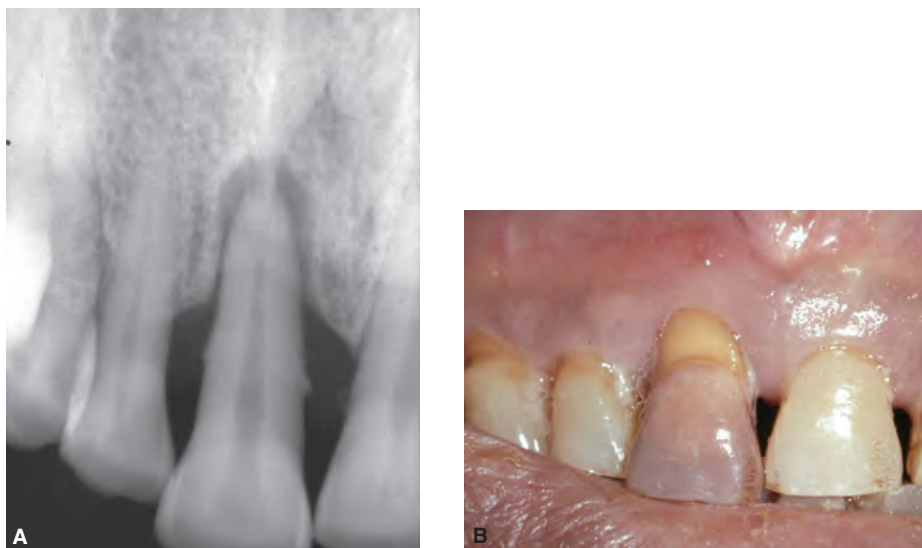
True combined endodontic–periodontal disease in a maxillary central incisor. A. Radiograph showing bone loss in two-thirds of the root with calculus present and separate periapical radiolucency. B. Clinical examination revealed coronal color change of the tooth involved and pus draining from the gingival crevis. Pulp sensibility tests were negative.
